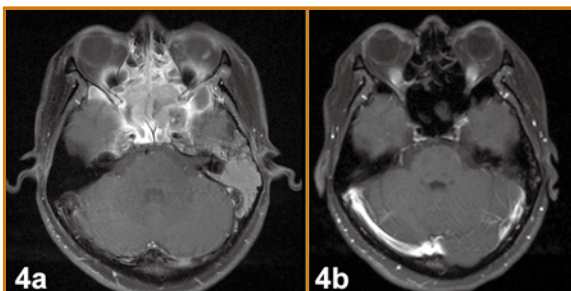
Effect of neoadjuvant CT on reduction of tumour invasion of sphenoid and ethmoid (a) Pre-CT MRI (b) Post-CT MRI
